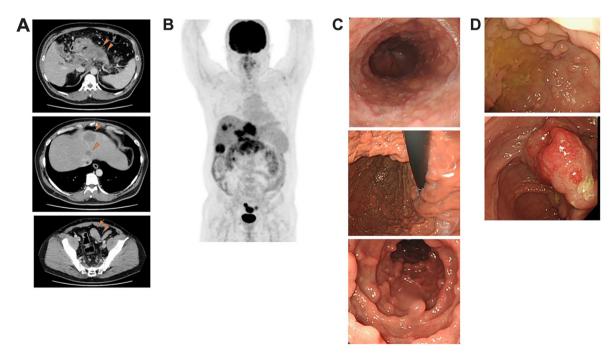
Key images. (A) Contrast-enhanced computed tomography (CT) scans: (top) A hypodense mass in the pancreatic head to body; (middle) Multiple liver masses; (bottom) Wall thickening with contrast enhancement in the sigmoid colon. (B) Positron emission tomography (PET)/CT: Fluorodeoxyglucose (FDG) uptake in the pancreas, liver, and sigmoid colon. (C) Upper gastrointestinal endoscopy: (top) Esophageal glycogenic acanthosis; (middle) Multiple gastric polyps; (bottom) Multiple duodenal polyps. (D) Lower gastrointestinal endoscopy: (top) Multiple polyps throughout the colon; (bottom) Type 1 tumor in the sigmoid colon.
